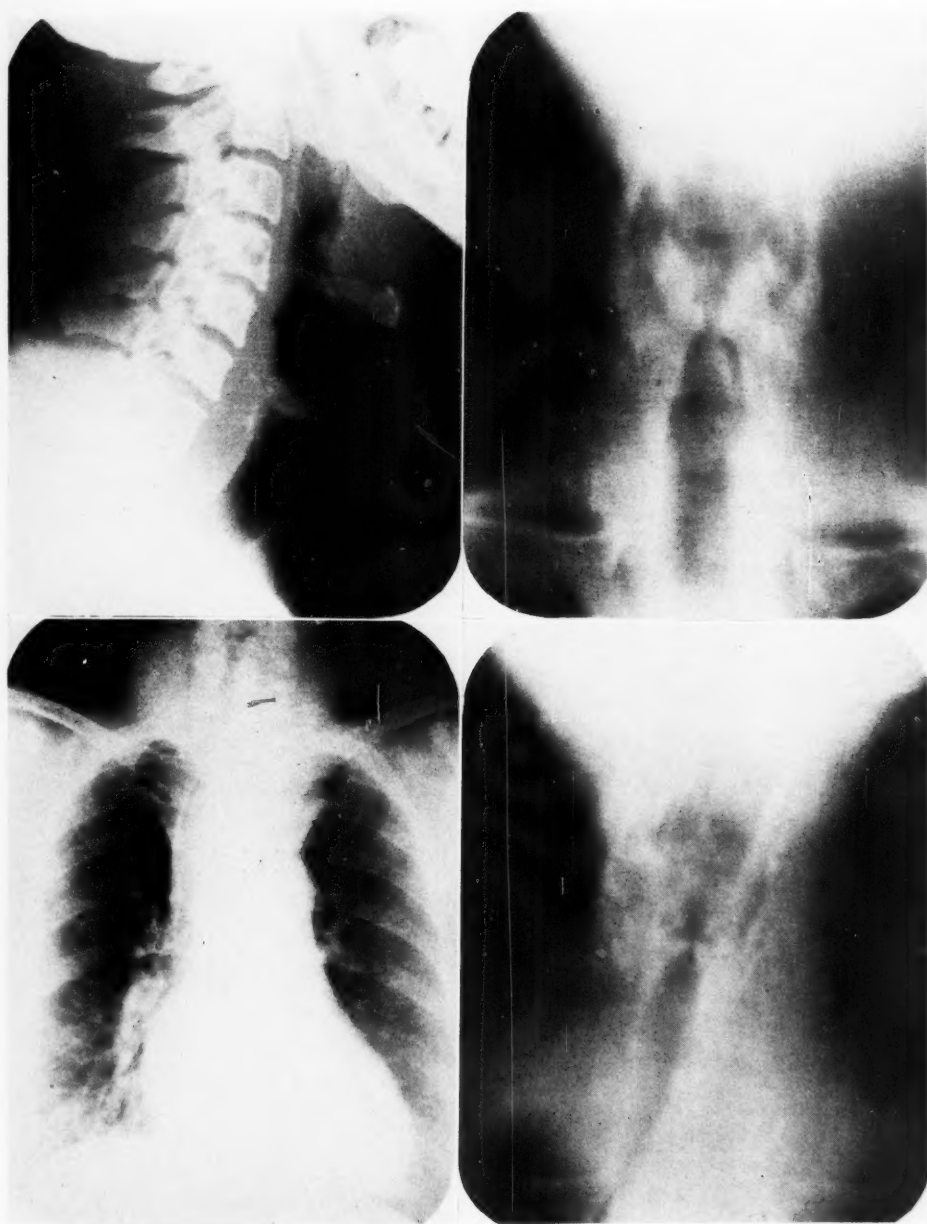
A (*upper left*). Lateral x-ray of neck, lymphosarcoma.
